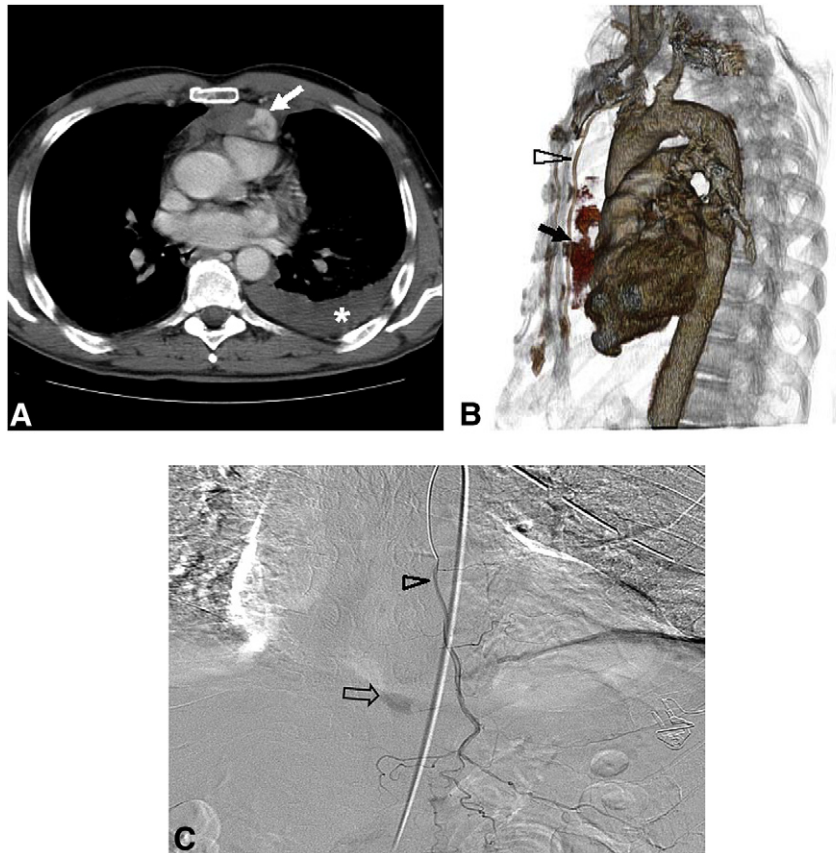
Computed tomography scan of the chest (A); sagittal three-dimensional volume rendering reconstruction (B) and pre-operative angiography (C) show the left hemothorax (asterisk in A), the active bleeding within the anterior mediastinal hematoma (arrow in A, B, and C), and the course of left mammary artery (arrowhead in B and C).
